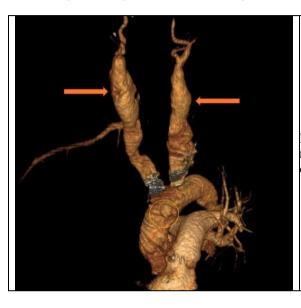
CT angiography showing circumferential mural thickening with dilatation of both common carotid arteries.
